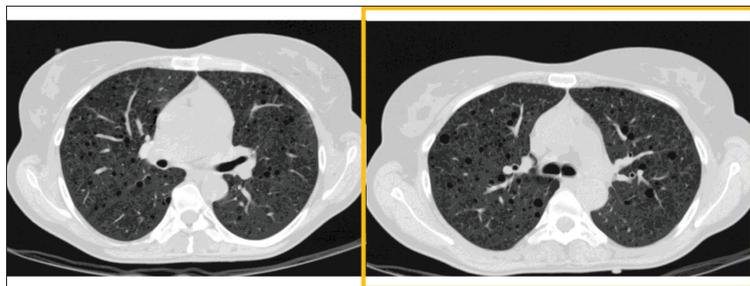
Chest high-resolution computed tomography of the patient with lymphangioleiomyomatosis after four years of therapy
